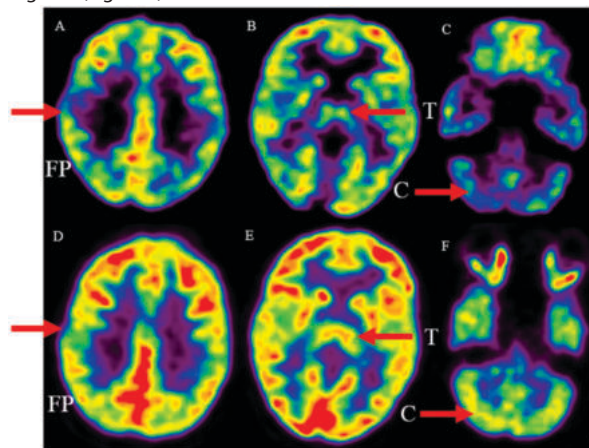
(A-C) Pre cell transplantation PET CT scan images showing hypometabolism in bilateral Bilateral fronto-parietal cortex (FP), Thalamus (T), and cerebellum (C) regions respectively. (D-F) Post cell transplantation PET CT scan images demonstrating improved metabolism in these areas
